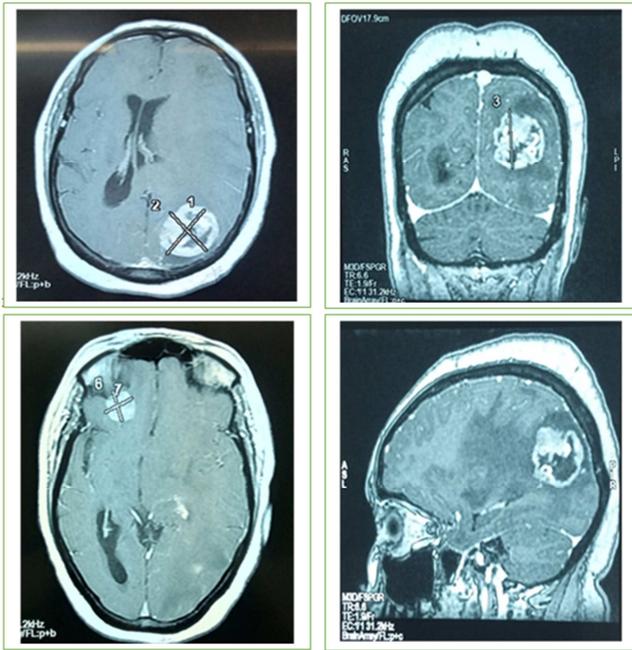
Images of brain magnetic resonance imaging.
